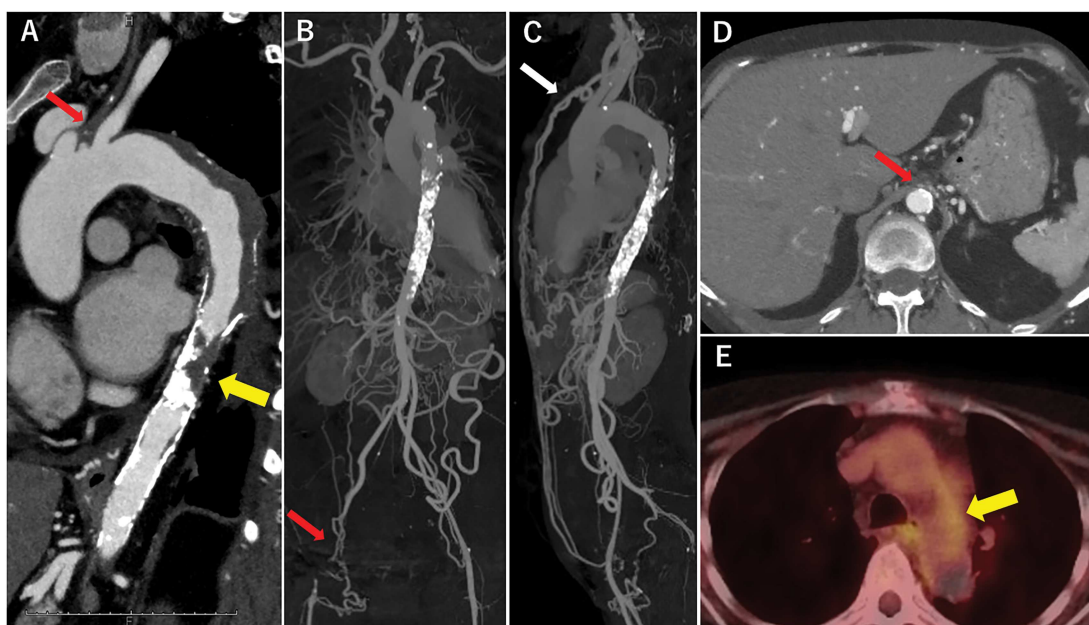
Atypical aortic coarctation complicating Takayasu's arteritis. (A) The contrast enhanced computed tomography (CT) revealed atypical aortic coarctation (AAC) of the descending thoracic aorta (yellow arrow). (A–D) The CT also showed occlusion of left common carotid artery, right external iliac artery, superior mesenteric artery, and celiac artery (red arrows), and collateral circulation from bilateral internal mammary arteries (white arrow). (E) The positron emission tomography revealed partial accumulation in the aortic arch (yellow arrow), and the patient was diagnosed with Takayasu's arteritis (TA).
